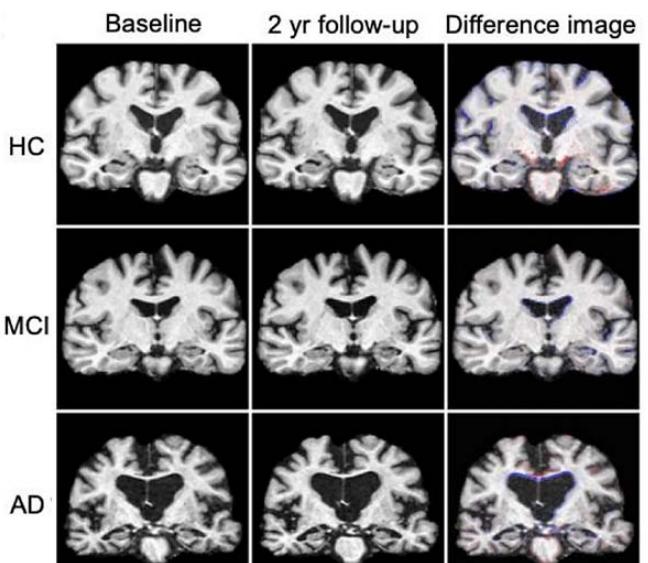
MRI images of healthy control (HC) subject, mild cognitive impairment (MCI) subject who converted to AD after three years, and an AD patient<sup>13</sup>
